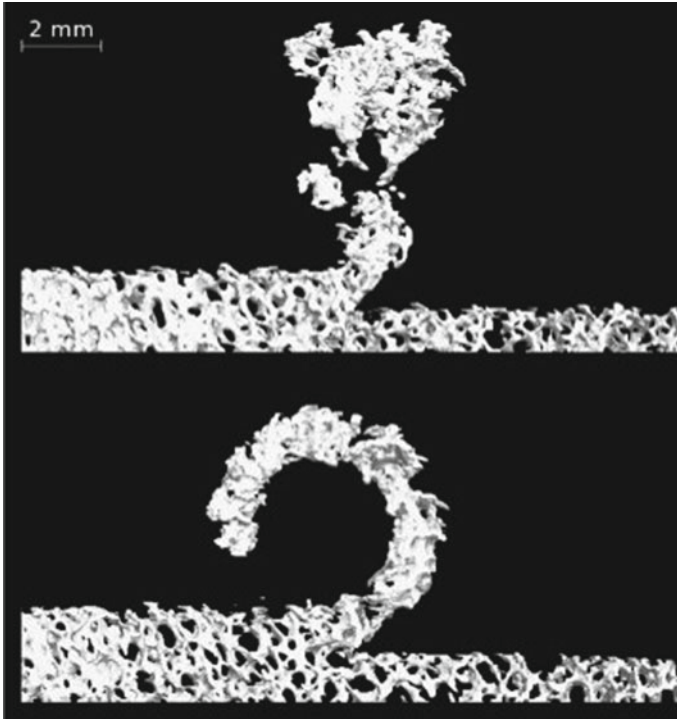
CT scans showing discontinuous chip at rake angle of 23° (*top* photograph) and continuous chip for rake angle of 45° at 1.2 mm depth of cut (*bottom* photograph) (reprinted from Malak and Anderson [15] with permission. © Elsevier)
